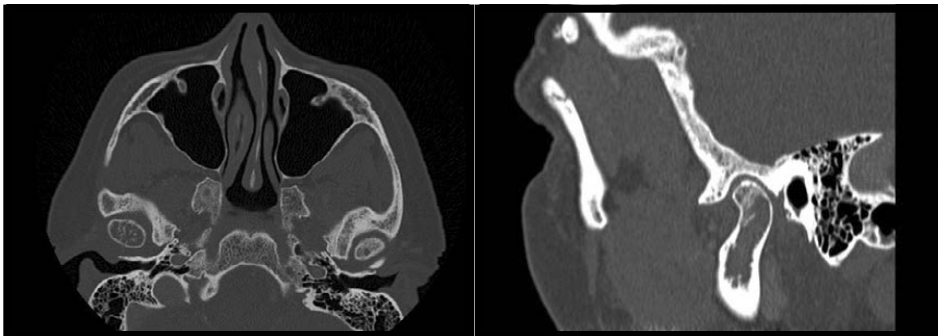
Sagittal and axial maxillofacial CT demonstrated lytic appearance of enlarged right mandibular condyle with increased trabeculation. No significant bony erosion, right temporomandibular joint space is preserved.
